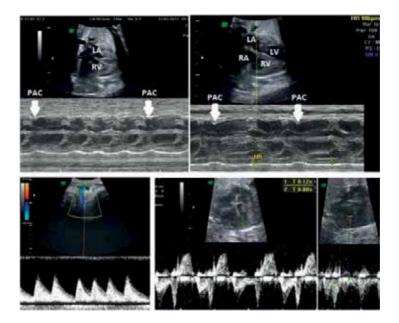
Fetal bradyarrhythmia, M-mode and pulsed Doppler evaluation. Premature atrial contractions (PACs, highlighted with arrows) are blocked, resulting in bradycardic irregular cardiac rhythm. Normal values for the mechanical PR interval by pulsed Doppler interrogation at the mitral-aortic region in prediction of heart block risk.
